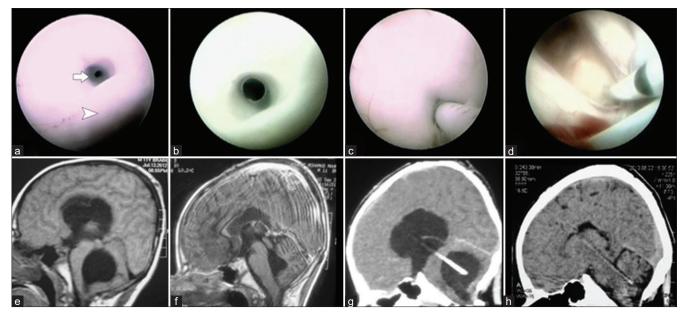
(a) Endoscopic view within the posterior third ventricle demonstrating the posterior commissure (arrow head) and membrane covering the aqueduct with tiny opening (arrow). (b) Endoscopic view within the posterior third ventricle after balloon aqueductoplasty. (c) Aqueduct stenting using shunt tube. (d) Endoscopic view through the lateral ventricle before withdrawal of the endoscope. (e) Pre-operative sagittal T1 MRI showing ballooning of ventricular system. (f) Post-operative sagittal T1 MR image showing marked decline in all ventricular system size after stenting. (g) Early post-operative sagittal reconstructed CT image. (h) Late post-operative sagittal reconstructed CT image showing full resolution of all ventriculomegaly.
